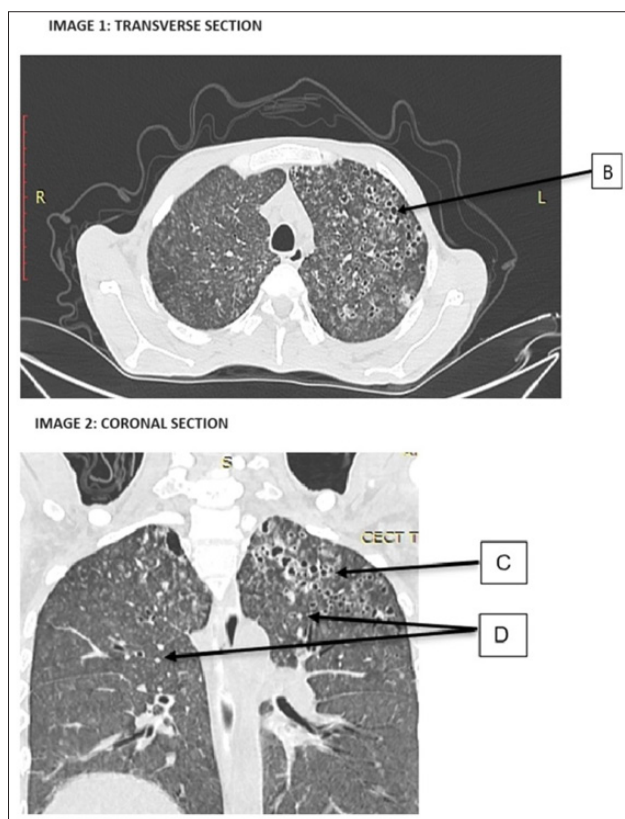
Contrast-Enhanced CT Scan Chest
